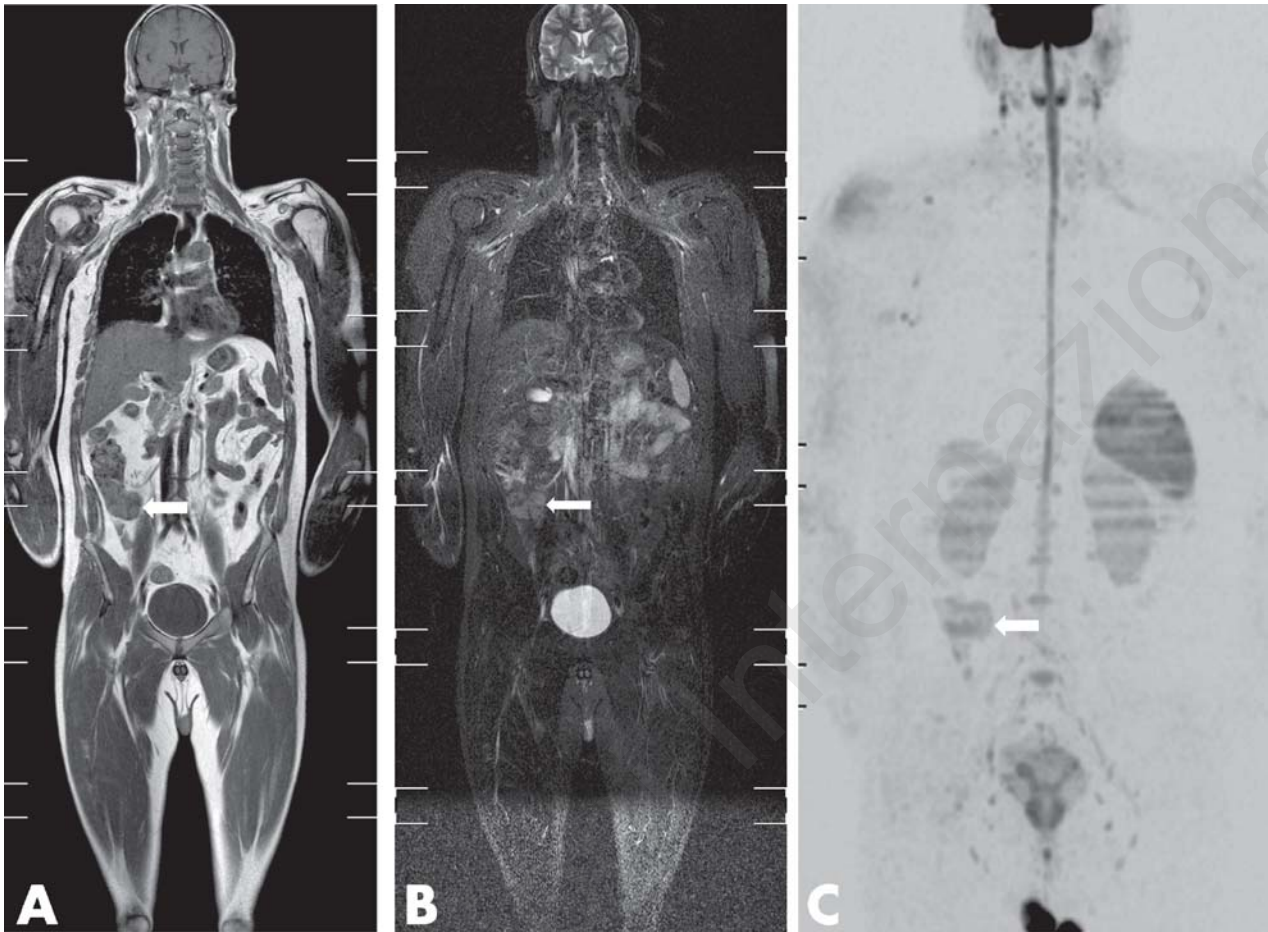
Caecal mass on WB-MRI.
